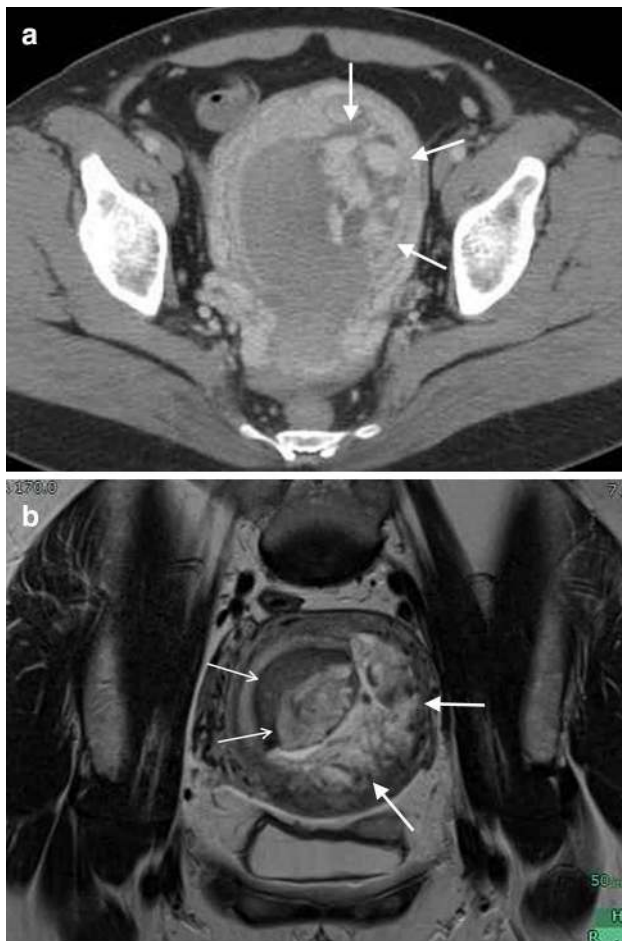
40-year-old woman with persistent genital bleeding 3 weeks after dilation and curettage for molar pregnancy with markedly elevated serum human chorionic gonadotropin. a Contrast-enhanced CT shows marked enhancement of the mass (arrows), which protrudes into the endometrial cavity. b MRI shows a hyperintense mass in the left side of the uterine wall (arrows), with myometrial invasion on T2-weighted imaging. Blood clots are also seen in the uterine cavity as masses with low to high signal intensity (small arrows)
